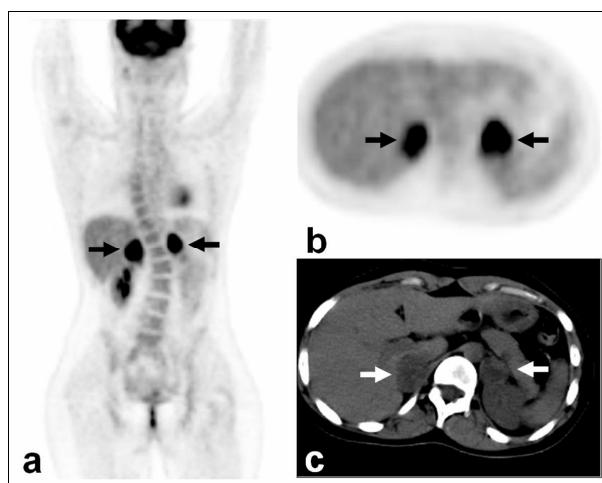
Coronal and axial F-18 FDG PET (a, b) and axial unenhanced CT (c) images revealed marked degree of abnormal FDG uptake in the adrenal pheochromocytomas bilaterally.
